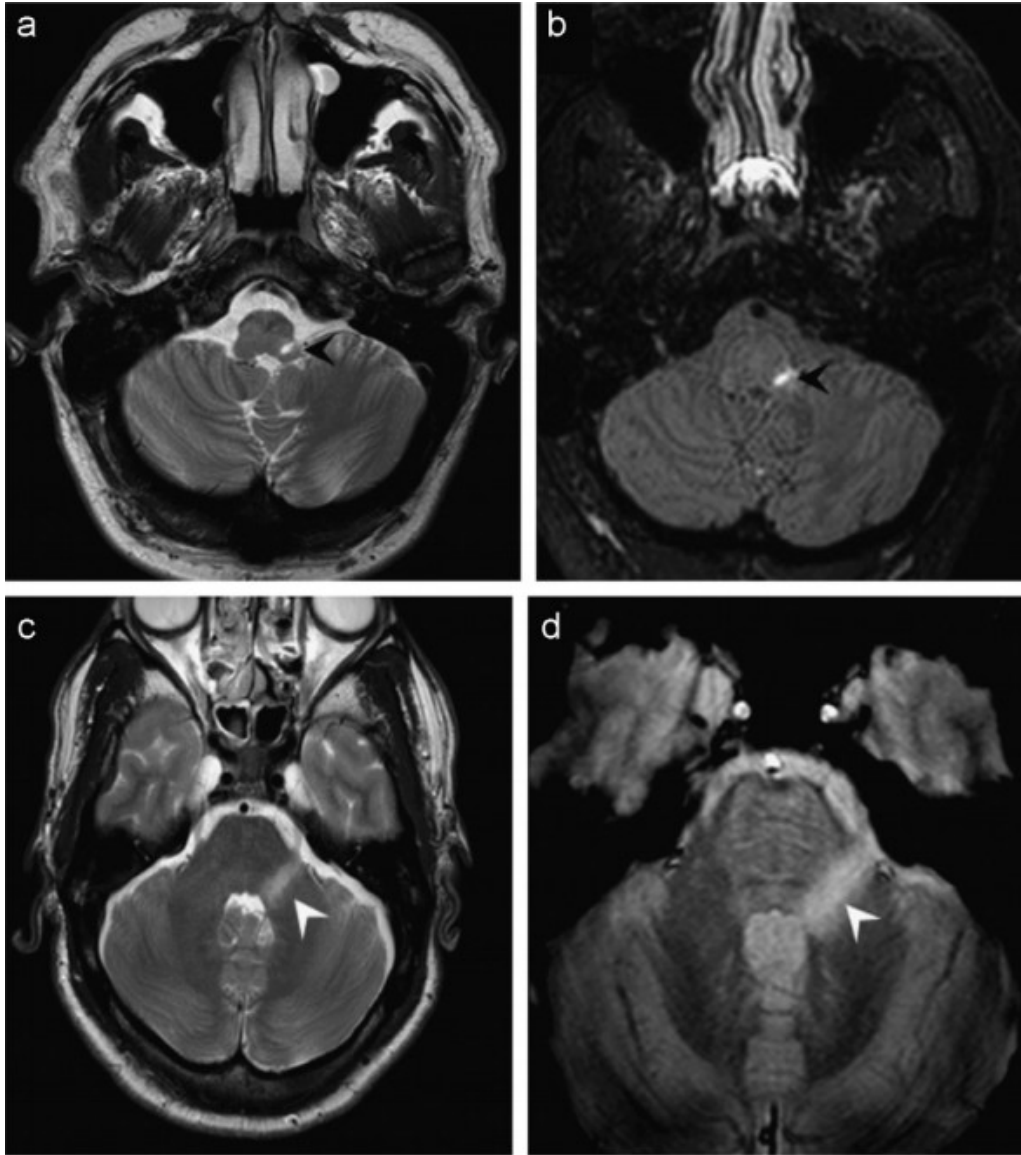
MRI images showing MS lesions [21].
